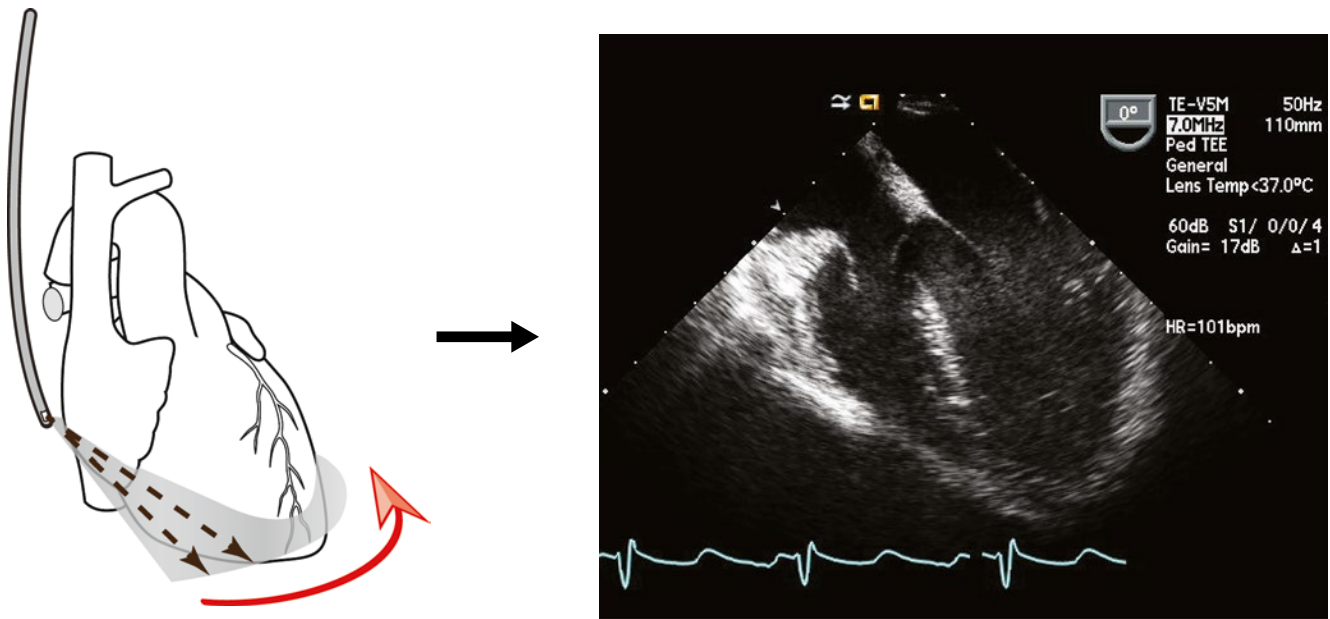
Production of an ultrasound (echocardiographic) image. A pulse of ultrasound is transmitted in a well defined beam, and the transducer “listens” while echoes are received from the same beam path. These echoes appear as *dots* (brightness) corresponding to signal amplitude.
